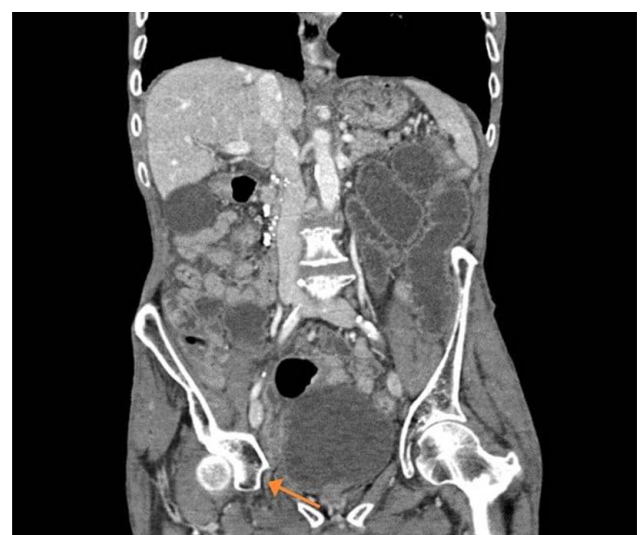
Computed tomography of abdomen and pelvis (axial view) showing right-sided obturator hernia.
